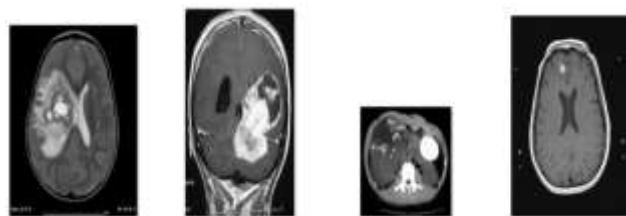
The benign and malignance brain tumour CT scan image examples used for the tumour detection model evaluation
